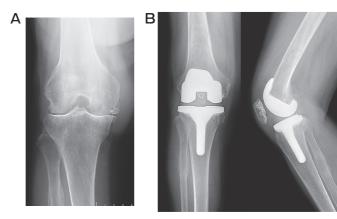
Radiographs before and after the patient's total knee arthroplasty (TKA). A, Preoperative radiograph of the knee; B, Radiograph 3 months after the TKA.
